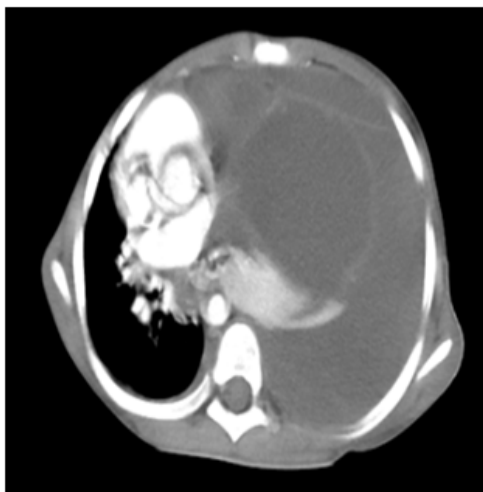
Axial contrast-enhanced CT (CECT) chest image demonstrating a large, well-defined fluid attenuation collection occupying the right hemithorax with compressive collapse of the adjacent lung parenchyma and contralateral mediastinal shift
